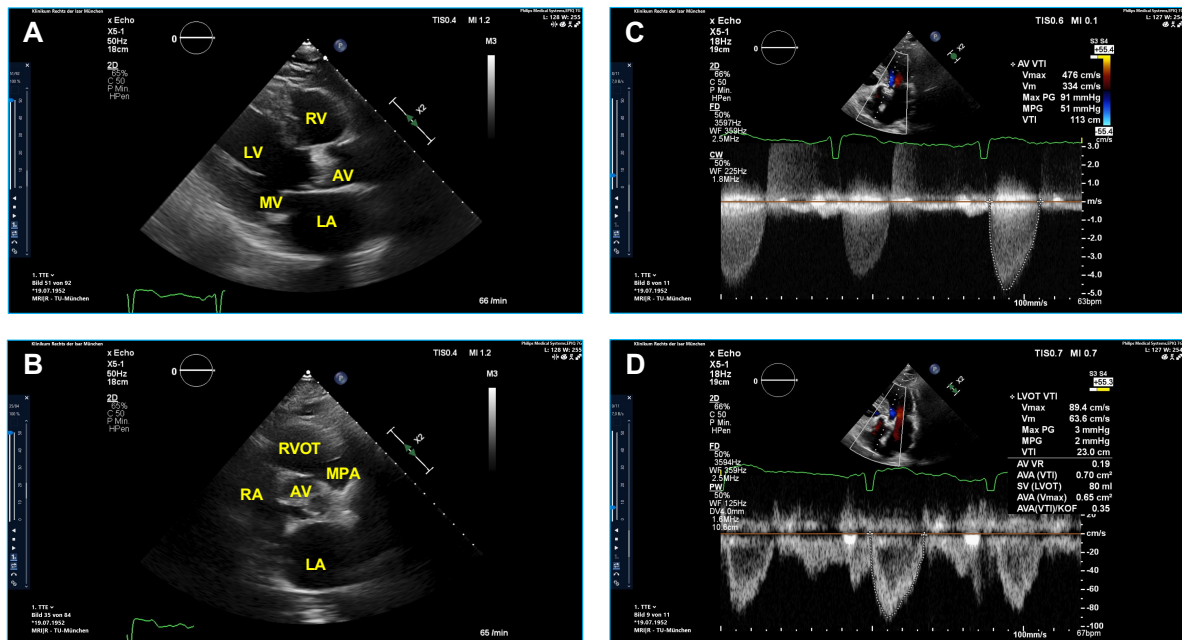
Transthoracic echocardiography in a patient presenting with severe aortic stenosis.
